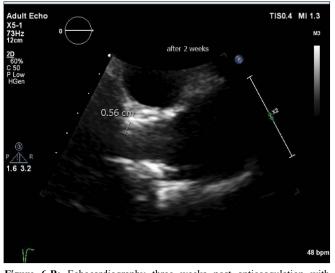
Echocardiography three weeks post anticoagulation with decreased thrombus size.
